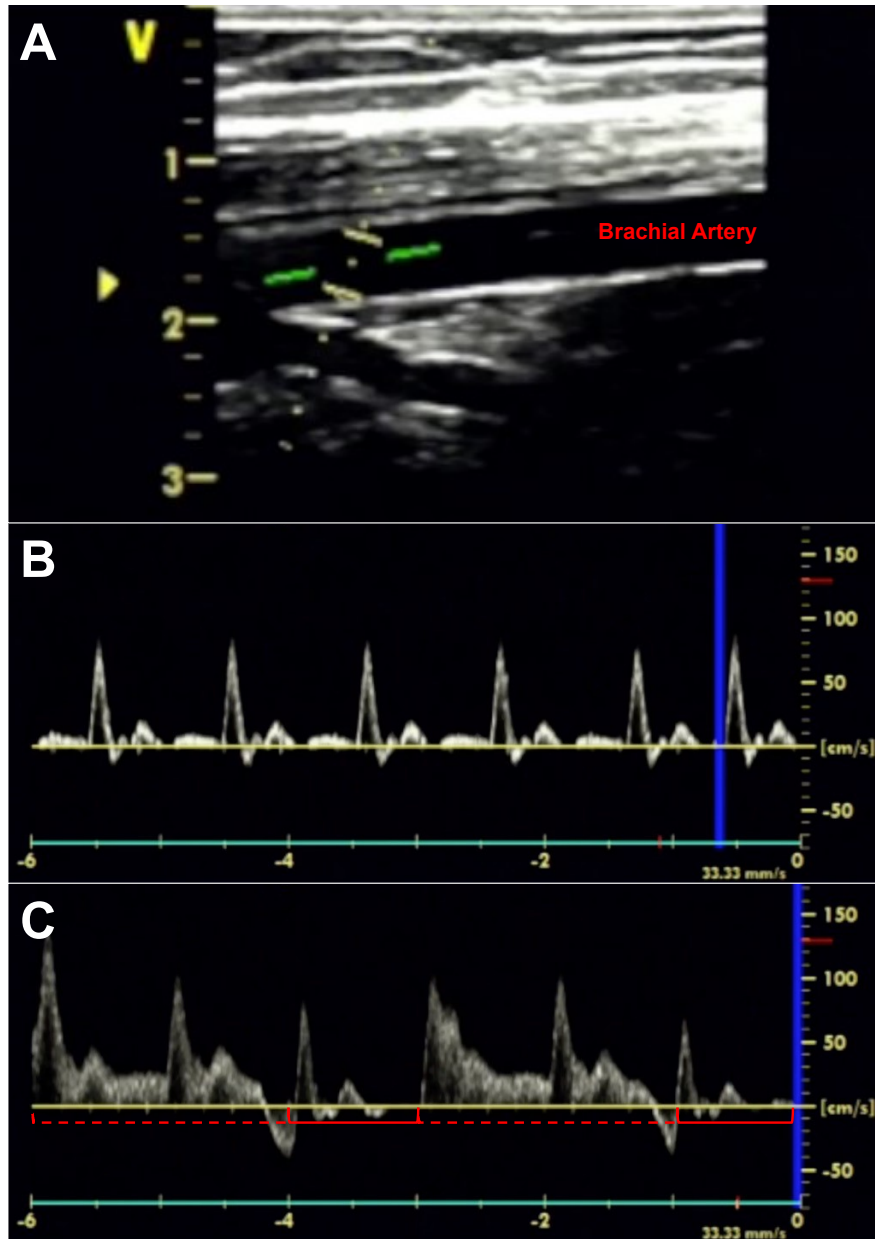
Brachial artery ultrasound images and Doppler velocity signals. B-mode image highlighting a longitudinal section of the brachial artery, as utilized for diameter analysis (A), with associated Doppler flow velocity signals over 6-second periods during quiet rest (B) and rhythmic handgrip exercise (C). Rhythmic handgrip exercise produces epochs of low flow as increased intramuscular pressure compresses the vasculature during muscular contractions (solid red brackets) between epochs of high flow during relaxation intervals (hatched red brackets).
